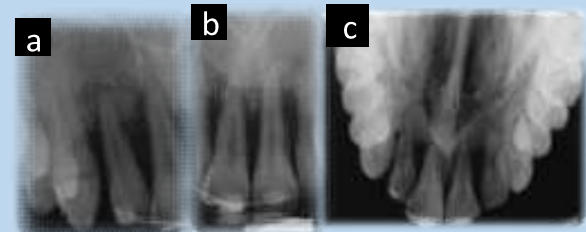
Radiographic examination consisted periapical, lateral periapical (a,b) and occlusal radiographs (c)
